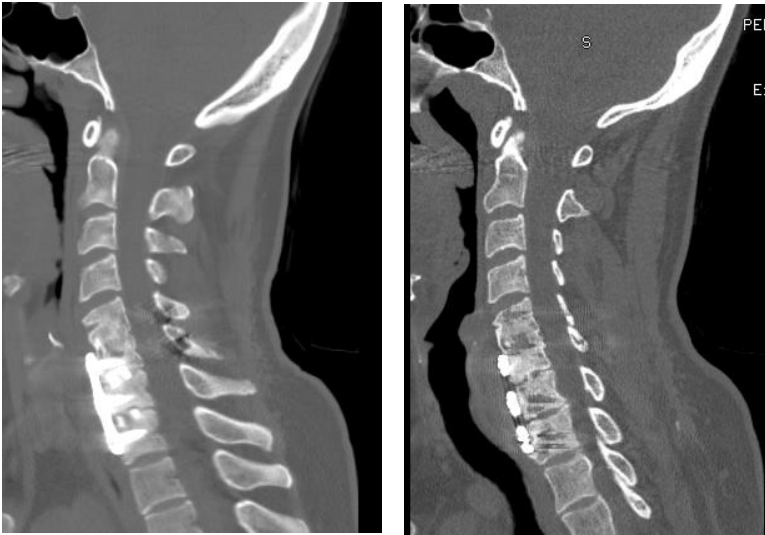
Sagittal CT of pseudoarthrosis at C6-7 and C7-T1.
